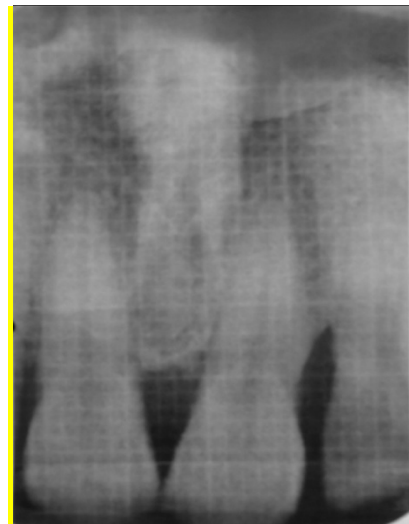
(e). X-Ray with Grid showing intra-bony defect between 21 & 22 at baseline
